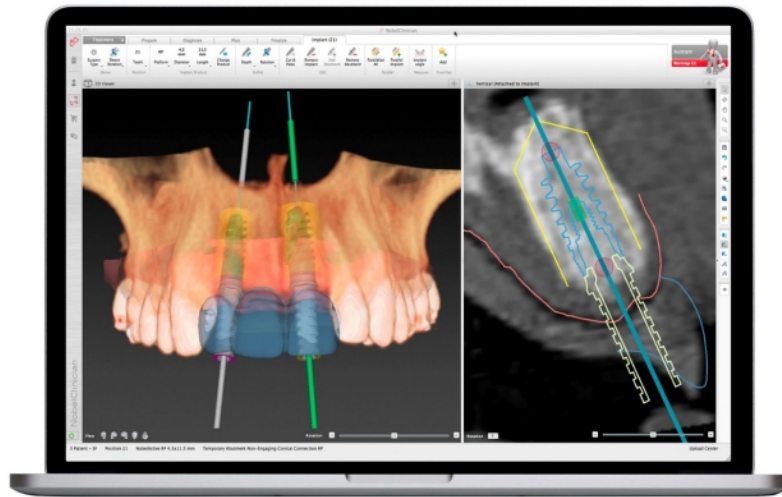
CBCT data viewing and surgery planning using NobelClinician™(source: <https://www.nobelbiocare.com>).
